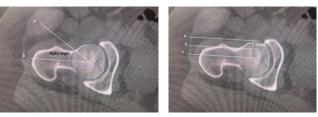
Oblique axial CT scan Figure 2. Oblique axial CT scan image showing alpha angle measurement.
